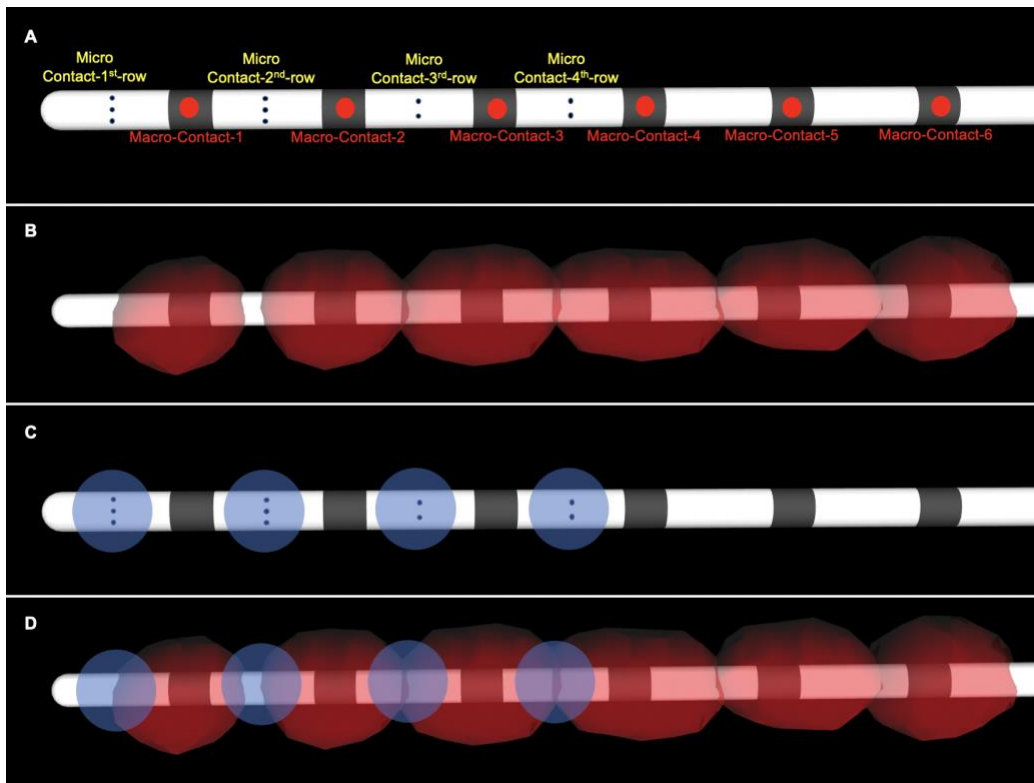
sEEG leads with sample macro-contact source regions and micro-contact target regions. The lead was reconstructed from CT scans using projection images and visualized in the DSI Studio package. (A) Lead specifications of the Ad-Tech MM16C sEEG lead. (B) Macro-contact source regions (red) detected from CT metal artifacts. (C) Micro-contact target regions (blue spheres) represent the estimated region that each micro-contact row can record from. (D) Representation of a reconstructed sEEG electrode with both macro- (red) and micro-contact regions (blue) visualized.
